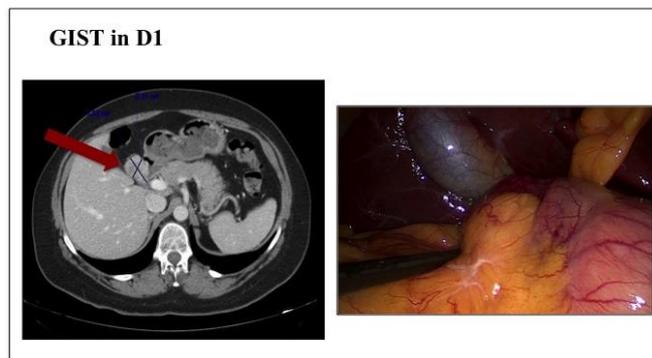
CT images of duodenal GIST depending on duodenal location, GIST in D1 (First duodenal portion), Arterial CT and tumor image during laparoscopic surgery
